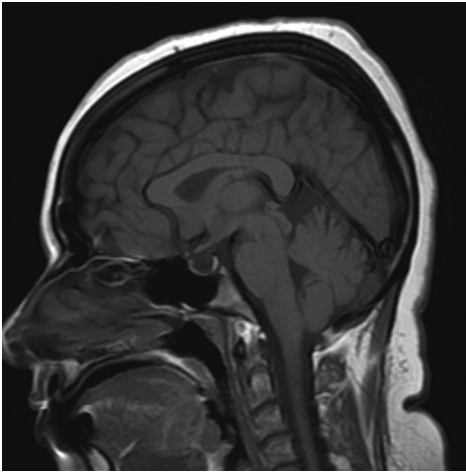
T1-weighted sagittal MRI image of the patient showing empty sella typically seen in idiopathic intracranial hypertension. MRI: Magnetic resonance imaging
